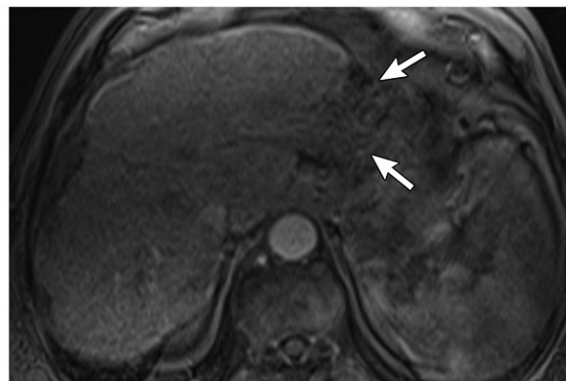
Complete tumor response to radiation segmentectomy in a 55-year-old man. (a) Axial pretreatment arterial phase MR image shows multiple HCCs (arrows) in liver segments II and III. (b, c) Axial arterial phase follow-up MR images obtained 3 months (b) and 6 months (c) after TARE show reduced size and devascularization of the treated lesions (arrows), with complete atrophy of the left lateral segment.
